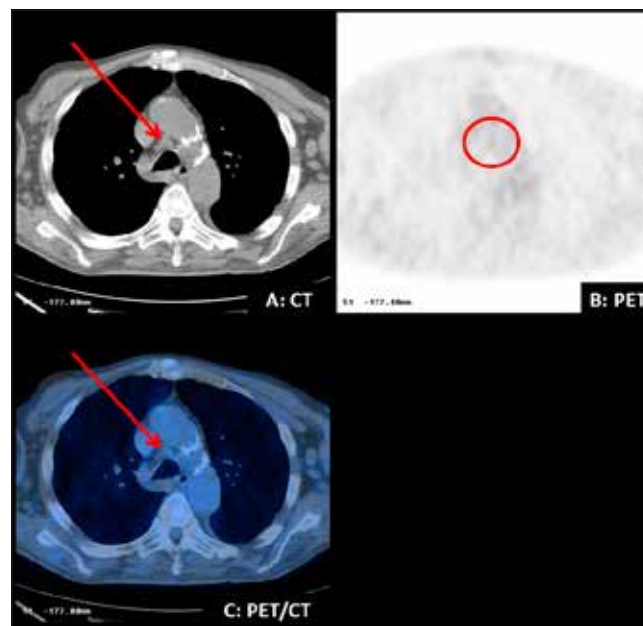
An axial slice on A: CT, on B: attenuated corrected PET and on C: Fused PET/CT on a patient with a false negative pre-tracheal lymph node on PET. Although the CT image suggests nodal positivity by size criteria, the PET (region of interest denoted by red circle) does not demonstrate any significant uptake in this region. The enlarged node was positive at surgery.
